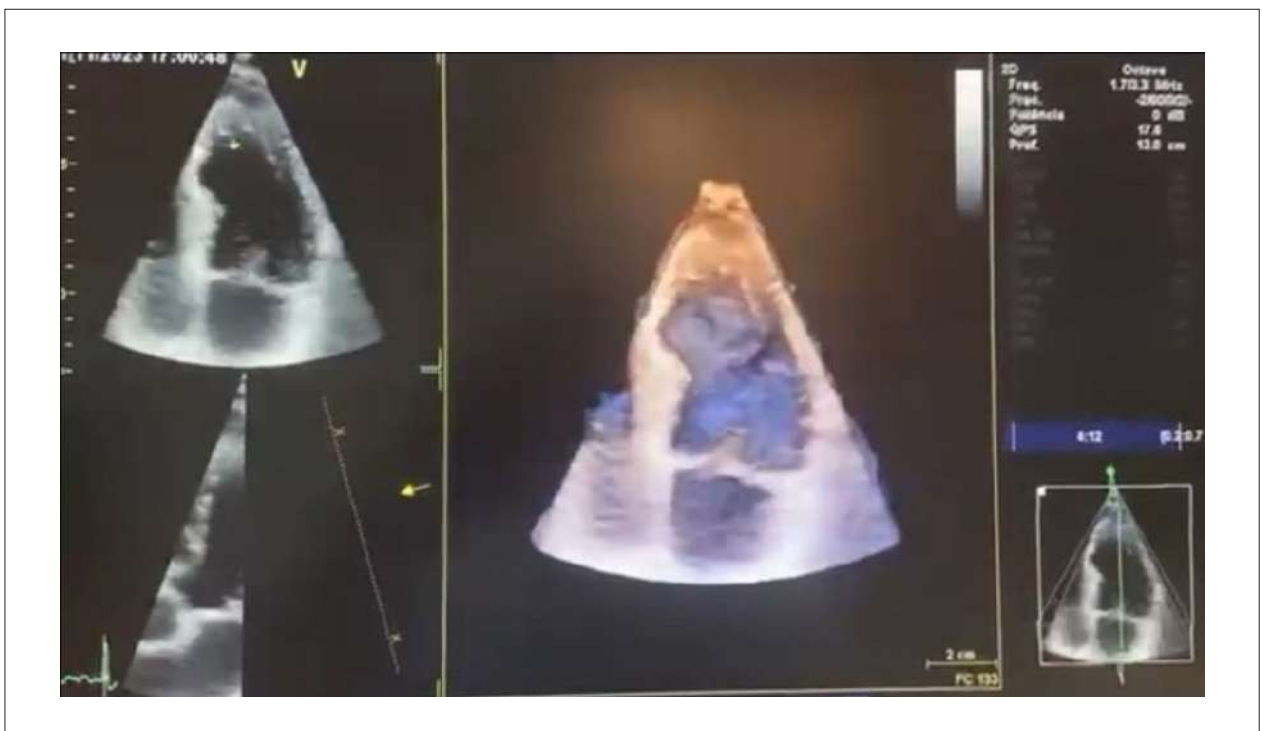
Three-dimensional imaging in stress echocardiogram.
